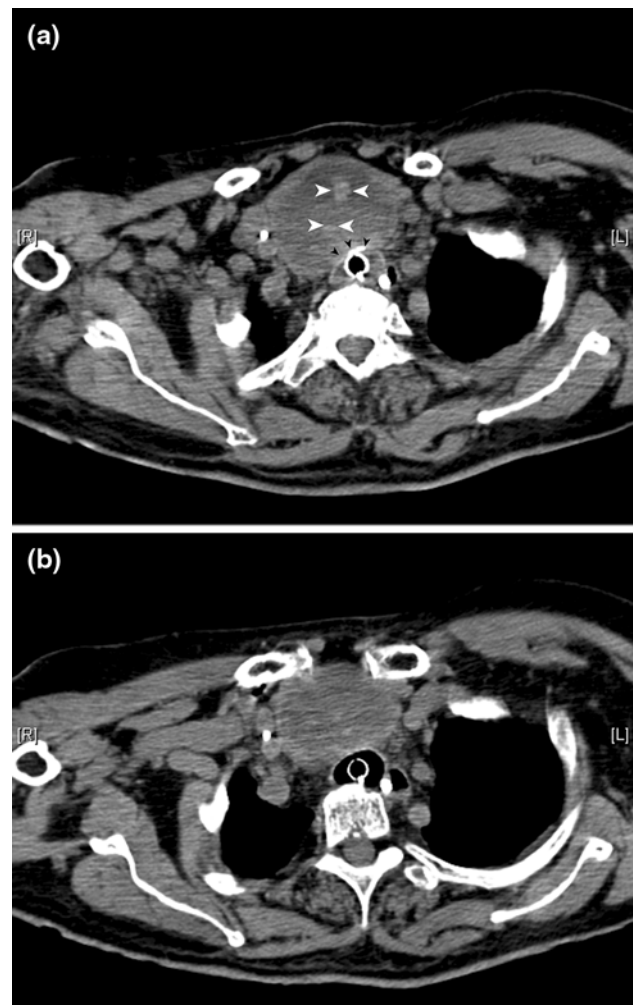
Transversal cervical computed tomography. a Thyroidal homogenous hypodense mass including smaller hyperdensities (white arrows) with tracheal and vascular compression (black arrows). b Intratracheal tube below the area of compression
